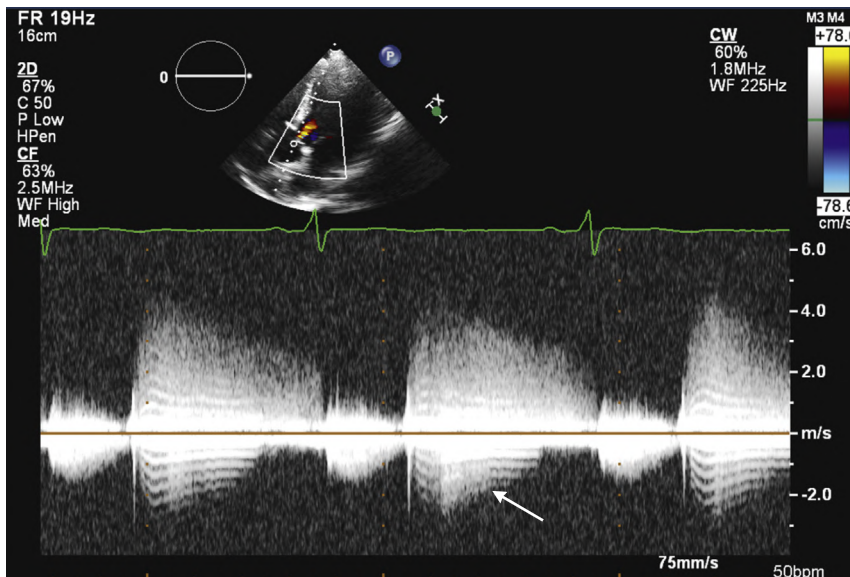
Doppler artifacts. Appropriate use of instrumentation allows minimization of many ultrasound artifacts. This recording of an aortic regurgitation velocity signal shows marked channel cross-talk (signal below the baseline that does not correlate with an actual intracardiac flow) due to high signal intensity with coarse fluttering of the incompetent valve leaflet. This recording would be improved by a higher wall filter and lower gain setting.
